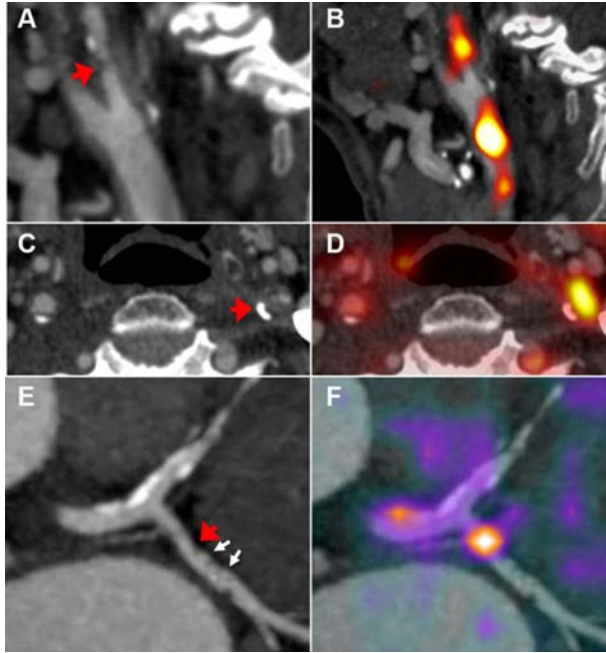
Examples of PET molecular imaging of atherosclerosis. Sagittal (A) and axial (C) CT angiographic views showing a plaque in the left internal carotid stenosis (red arrows). Fused sagittal (B) and axial (D) PET-CT images, showing high uptake of ^{18}F -FDG in the carotid artery of this symptomatic patient. (E) CCTA showing calcification in the left anterior coronary artery (bright signal at the bifurcation with the circumflex coronary artery) and only mild luminal disease in the left circumflex coronary artery (red arrow) with spotty calcification (white arrows). (F) Fused ^{68}Ga -DOTA-TATE PET-CT showing high uptake in plaque visualized in the left circumflex coronary artery. Source: fig. 4 of Ref. [19.29].
